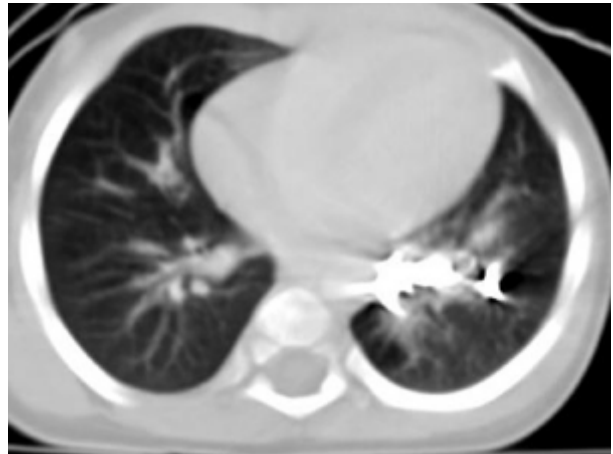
Immediate follow up CT scan showing multiple coils in systemic pulmonary artery, disappeared aorto-pulmonary shunt.
